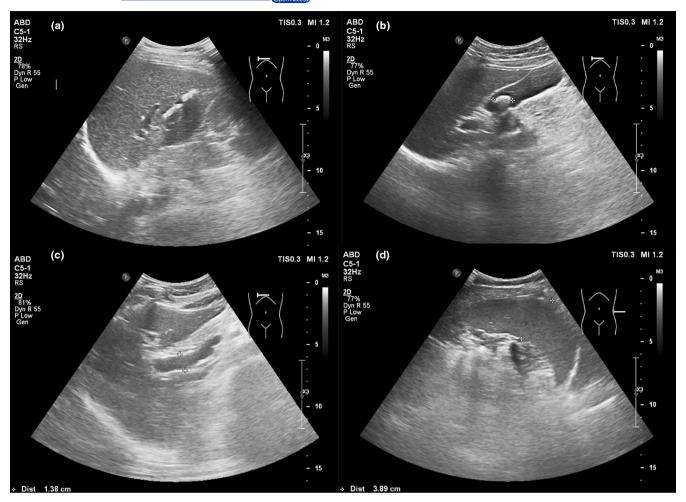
Abdominal ultrasound results of the symptomatic mother (II.2). (a) Intrahepatic bile duct stones (white arrow) with slight bile duct dilation; (b) Stone in the gallbladder (diameter 1.57 cm); (c) Portal vein (width 1.38 cm); (d) Splenic hilum thickness (3.89 cm).
